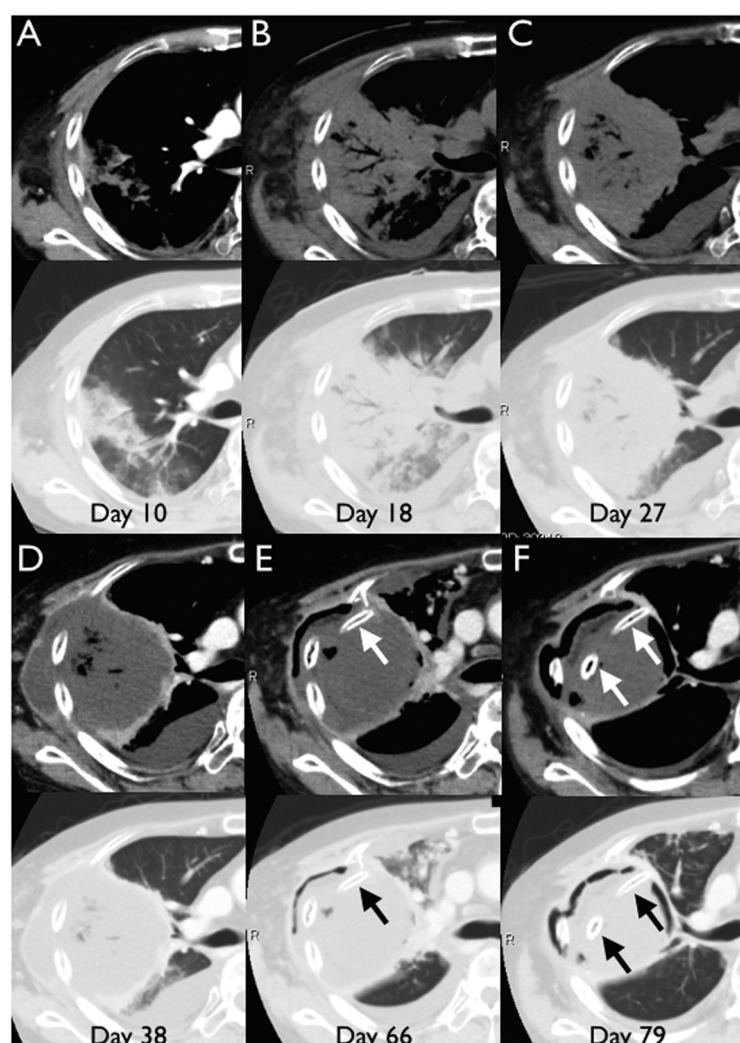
Chest computed tomography initially revealed infiltrates in the right upper lobe (A). The lesion subsequently invaded the chest wall (B, C) and eventually formed a cavity (D) with rib fractures (arrows) (E, F).
